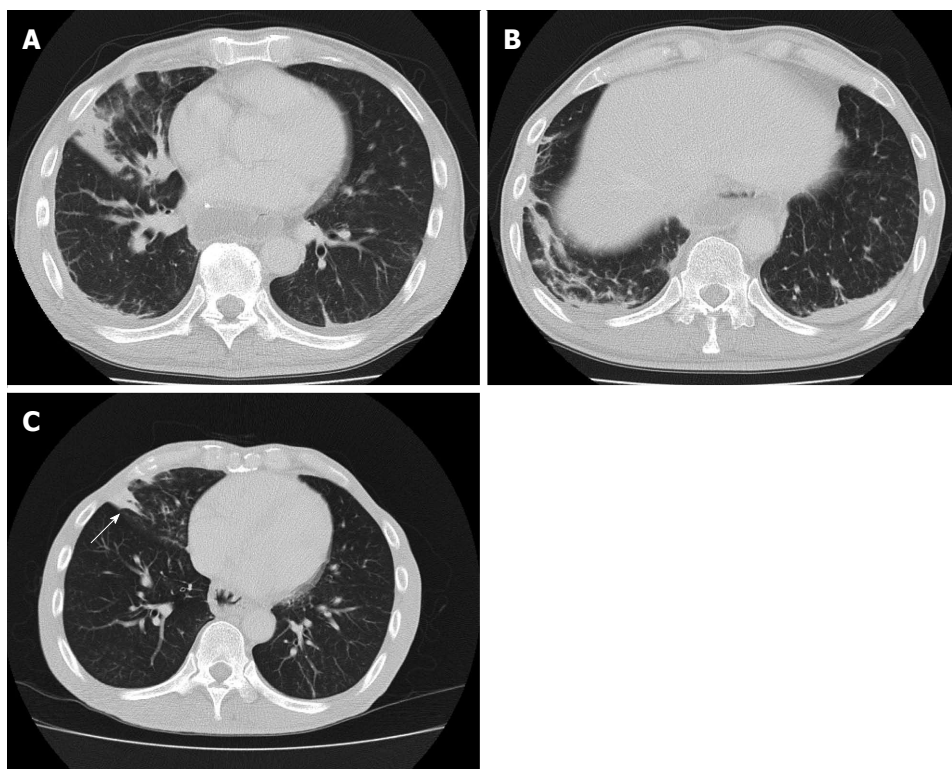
Unenhanced computed tomography after esophagectomy. A: Computed tomography (CT) revealed consolidation in the right middle lobe; B: CT simultaneously demonstrated consolidation in the right lower lobe (A and B); C: Although there was no evidence of newly developed pneumonia, consolidation remained in the right middle lobe 14 mo after esophagectomy (arrow).
